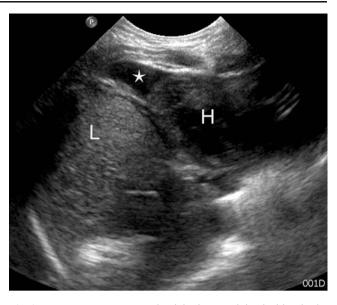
Transverse sonogram at the right thoraco-abdominal level. The liver (L) is seen at the level of the heart (H). There is a small amount of pleural fluid (*asterisk*). The findings suggest diaphragmatic hernia
